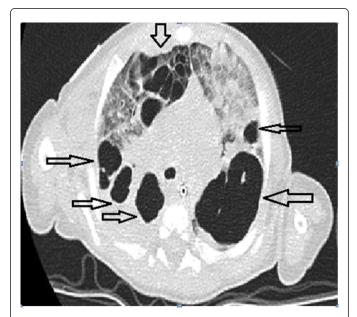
CT image showing multiple pneumatoceles and multiple areas of bilateral alveolar consolidation in the parenchyma not cavitated.
